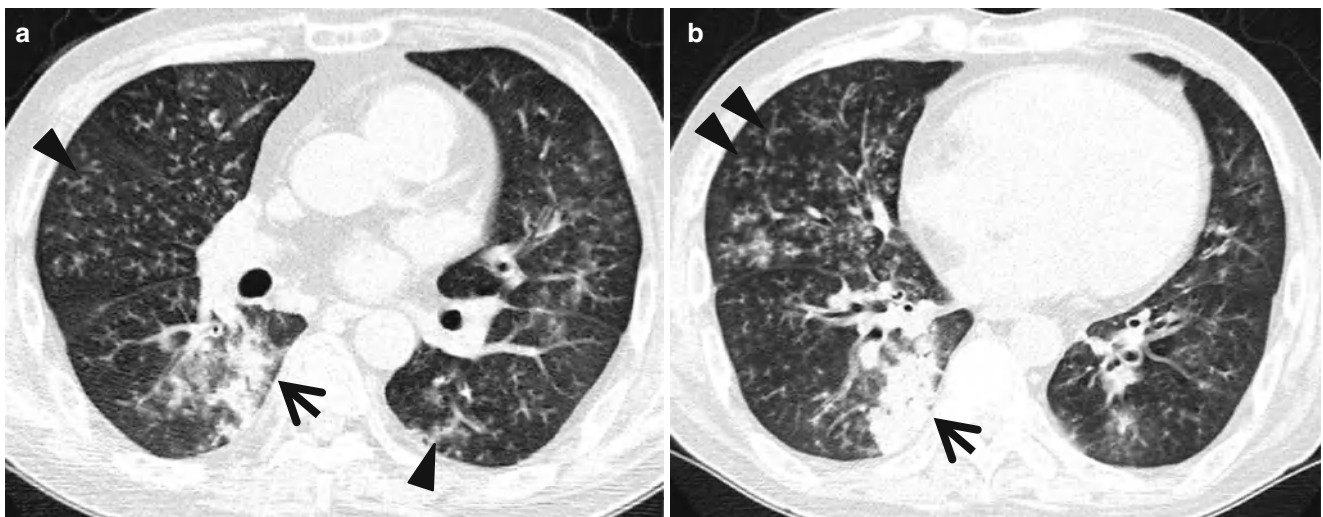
Airway-invasive pulmonary aspergillosis presenting as multifocal areas of consolidation and branching small nodular lesions in a 46-year-old man who had brain tumor and who received corticosteroid therapy. (a, b) Thin-section (1.0-mm section thickness) CT scans obtained at levels of the bronchus intermedius (a) and basal segmental
